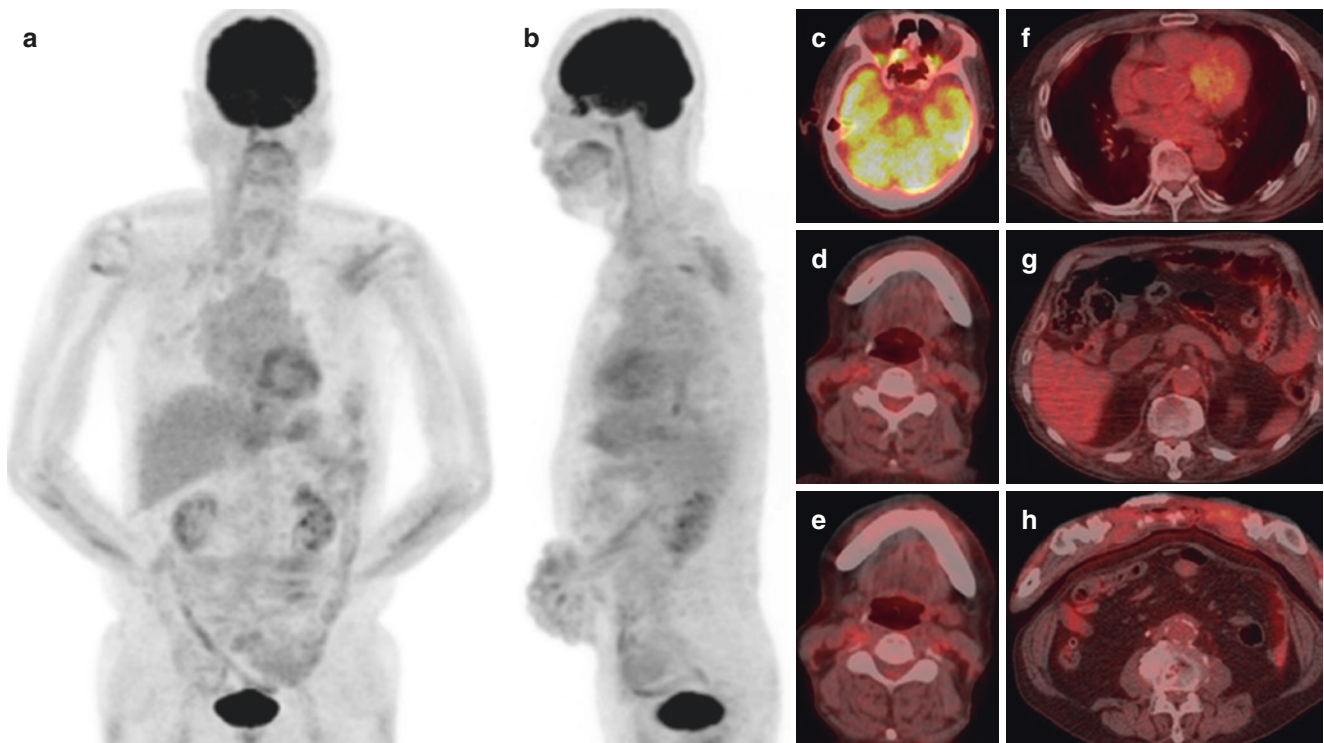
Biopsy of the lacrimal glands confirmed the diagnosis of IgG4-RD, and oral glucocorticoid therapy was initiated. ^{18}F -FDG PET/CT MIP (a, b) with fused images after 6 months of treatment revealed that the abnormal uptake in the lacrimal glands (c), salivary glands (d, e), pleura (f), pancreas (g), and periaortic retroperitoneal region (h) almost completely disappeared, indicating a good treatment response. The serum IgG4 levels were normalized
